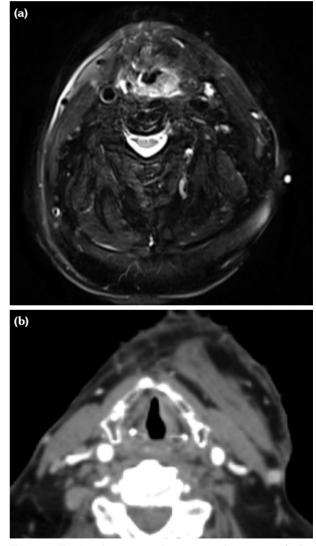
Axial computed tomography scan of the laryngeal tumor. (a) The tumor infiltrates into arytenoid cartilage and left aryepiglottic fold in left supraglottic area. (b) The tumor enters superior cornu of the thyroid cartilage.
